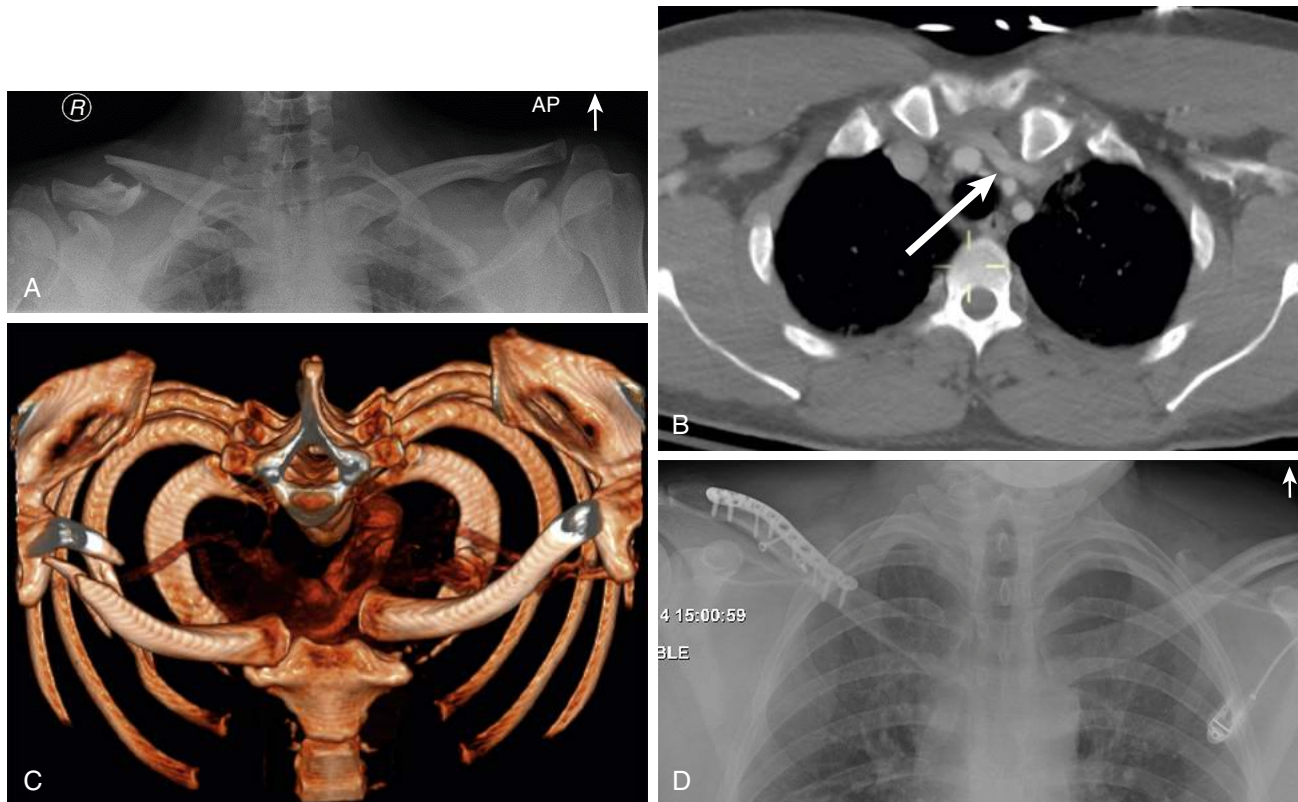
AP chest radiograph, axial CT slice and 3D reconstruction of the thorax of a 32 year old male trauma patient involved in a motor vehicle accident. The images demonstrate a displaced right midshaft clavicle fracture and posterior dislocation of the left sternoclavicular joint (A-C). The white arrow demonstrates abutment of the posteriorly dislocated clavicle on the left brachiocephalic vein. Postoperative AP chest radiograph following ORIF of the right midshaft clavicle and open reduction and suture stabilization of the left posterior sternoclavicular dislocation (D). Prior to taking this patient to the operating room the on call cardiothoracic surgeon was notified about the procedure. The patient's surgery was uncomplicated and he had an excellent clinical outcome. Used with permission from Nauth A and McKee MD. Humerus and shoulder: fractures and nonunions. In Grauer J.N. and Ring D., Eds. *Orthopaedic Knowledge Update 12* (pp. 299–320), 2017. Rosemount, IL: AAOS.
